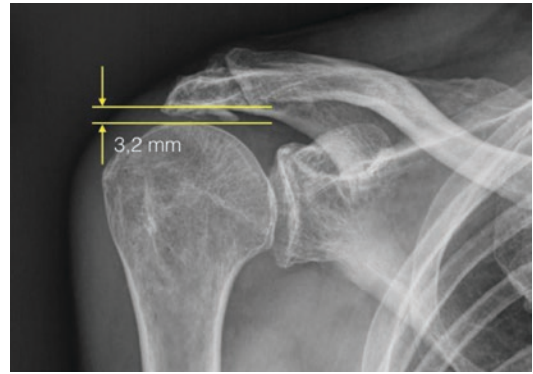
X-ray in AP view of a right shoulder in a 67-year-old male patient with a degenerative massive rotator cuff tear. The measured AHD in this case is less than 6 mm indicating a not completely reparable RCT
